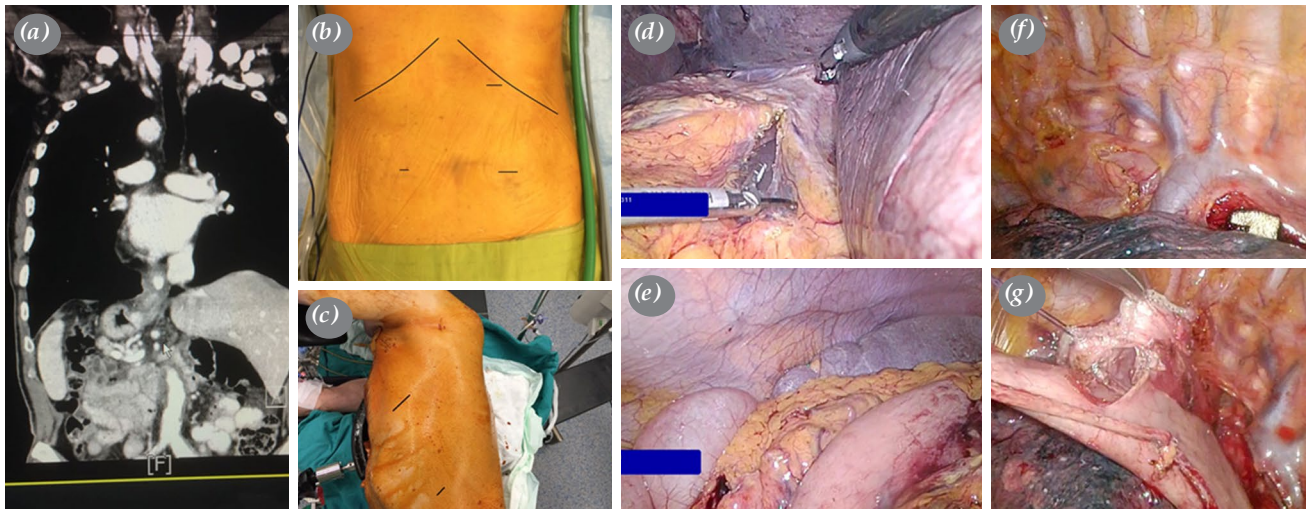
(a) Computed tomography section showing a mass at the gastroesophageal junction. (b) Laparoscopic port incisions; 5 mm right paramedian, 10 to 15 mm left paramedian and 10 to 12 mm left subcostal. (c) Thoracoscopic incisions; on the fifth intercostal space anterior axillary line and a second port on the eighth intercostal space posterior axillary line. (d) The gastrohepatic ligament is divided initially. (e) The greater curvature is freed while preserving the gastroepiploic artery. (f) Pleura over the esophagus is opened up to azygos vein over the pericardium, intermediate bronchus, and the carina. (g) Posterior wall anastomosis is completed for a double-barrel, completely stapled, side-to-side linear stapled intrathoracic anastomosis.
